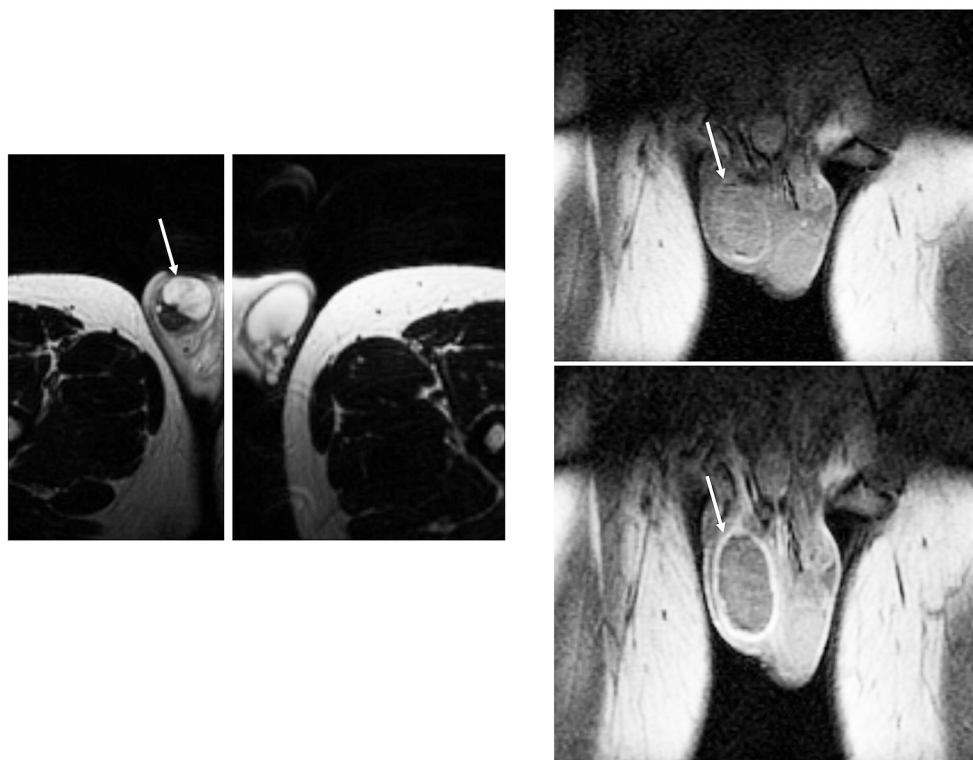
MRI-images of a 15-year-old boy with right sided testicular torsion for 48 hours. T2-weighted image on the left and T1-weighted images on the right side. In the right bottom T1-image with contrast media the necrotic testis is best demonstrated.
